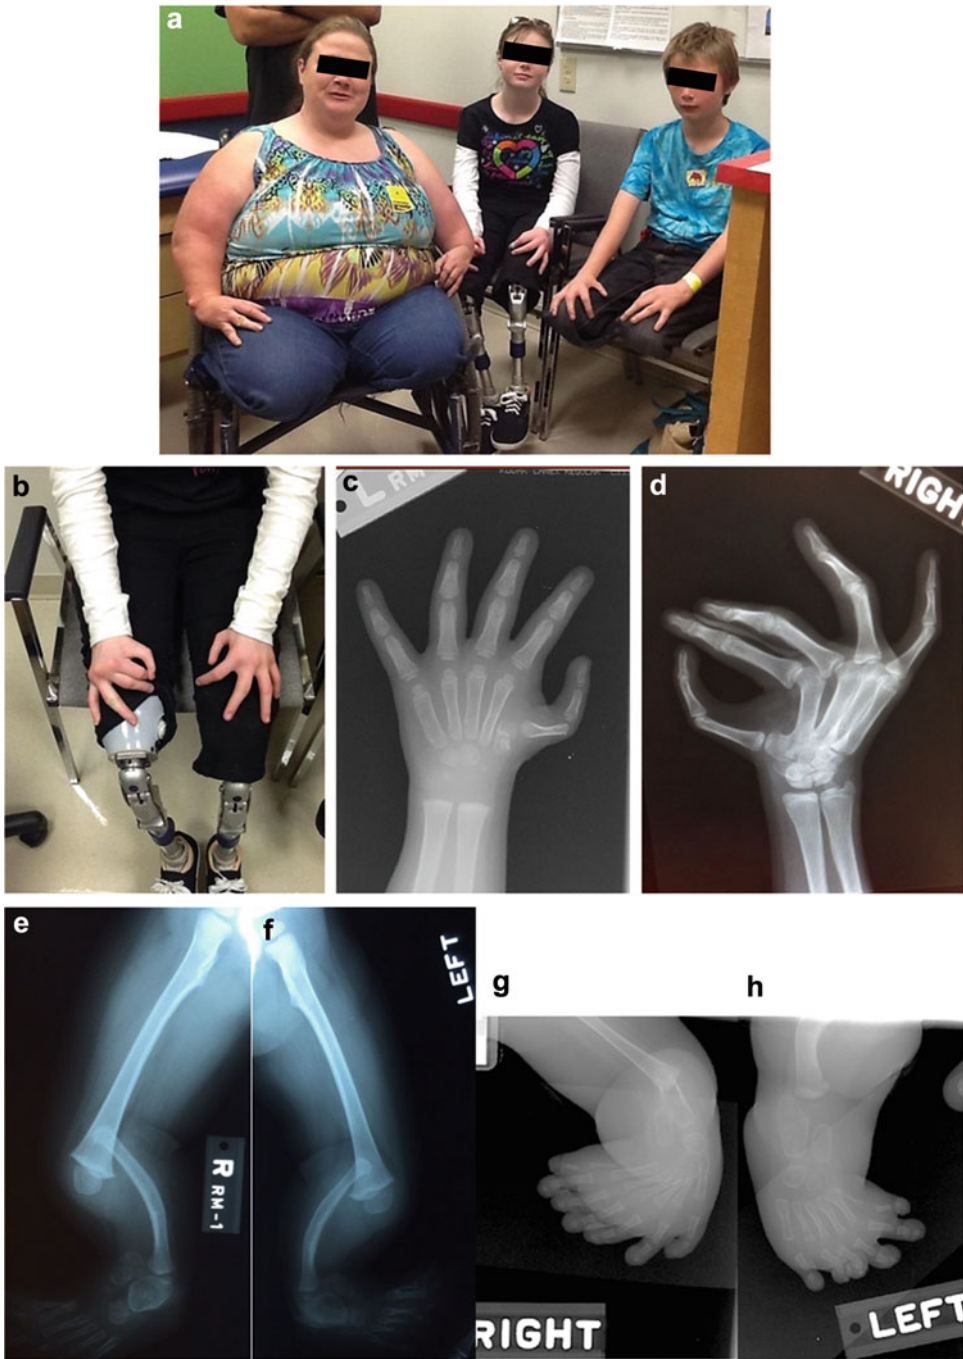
A 15-year-old female, her 14-year-old brother, and their mother (a) were evaluated for multiple abnormalities of the limbs, including bilateral tibial aplasia. She was born with five fingers (b) on the right with fingerlike thumb, five digits on the left hand (c), and radial deviation of the right 2nd–3rd fingers (d) (radiograph of the left hand at 3 years
